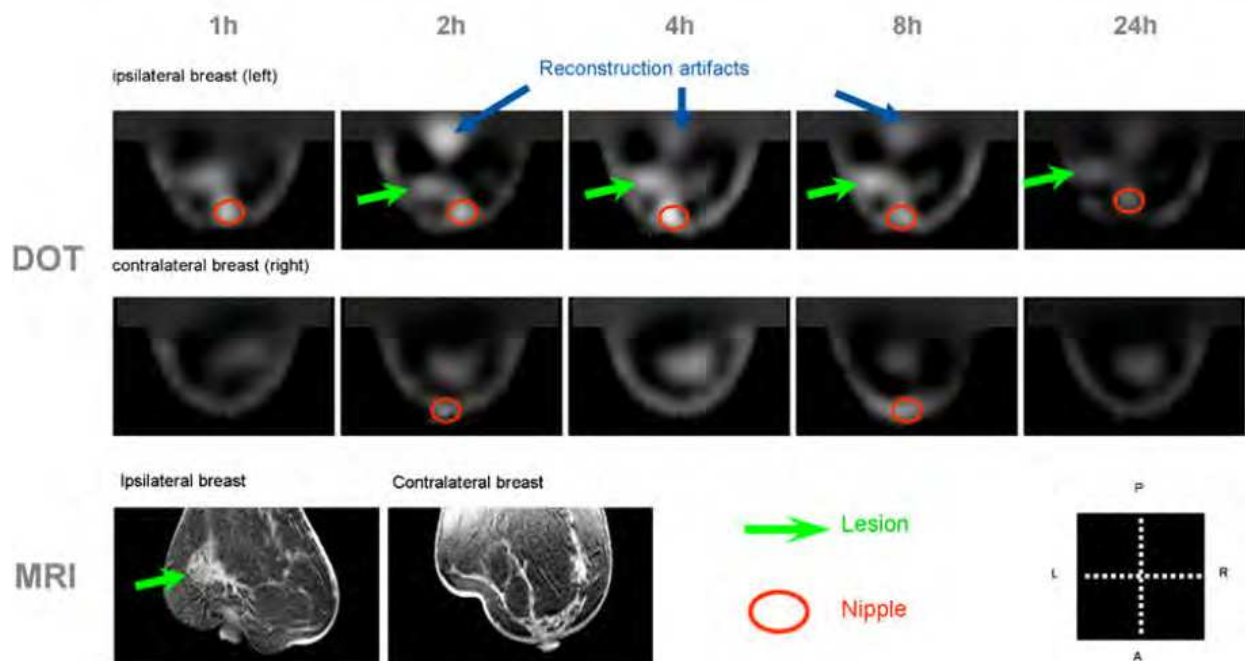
Contrast-enhanced DOT of the breast: Omocianine-enhanced DOT of a patient with invasive lobular carcinoma in the left breast (first row) with visible contrast agent accumulation in the region of the tumour. The contralateral breast (second row) showed no suspicious contrast enhancement. MRI corroborated the optically detected breast cancer lesions (bottom row) (van de Ven et al., 2010; reproduced with permission from Springer).
